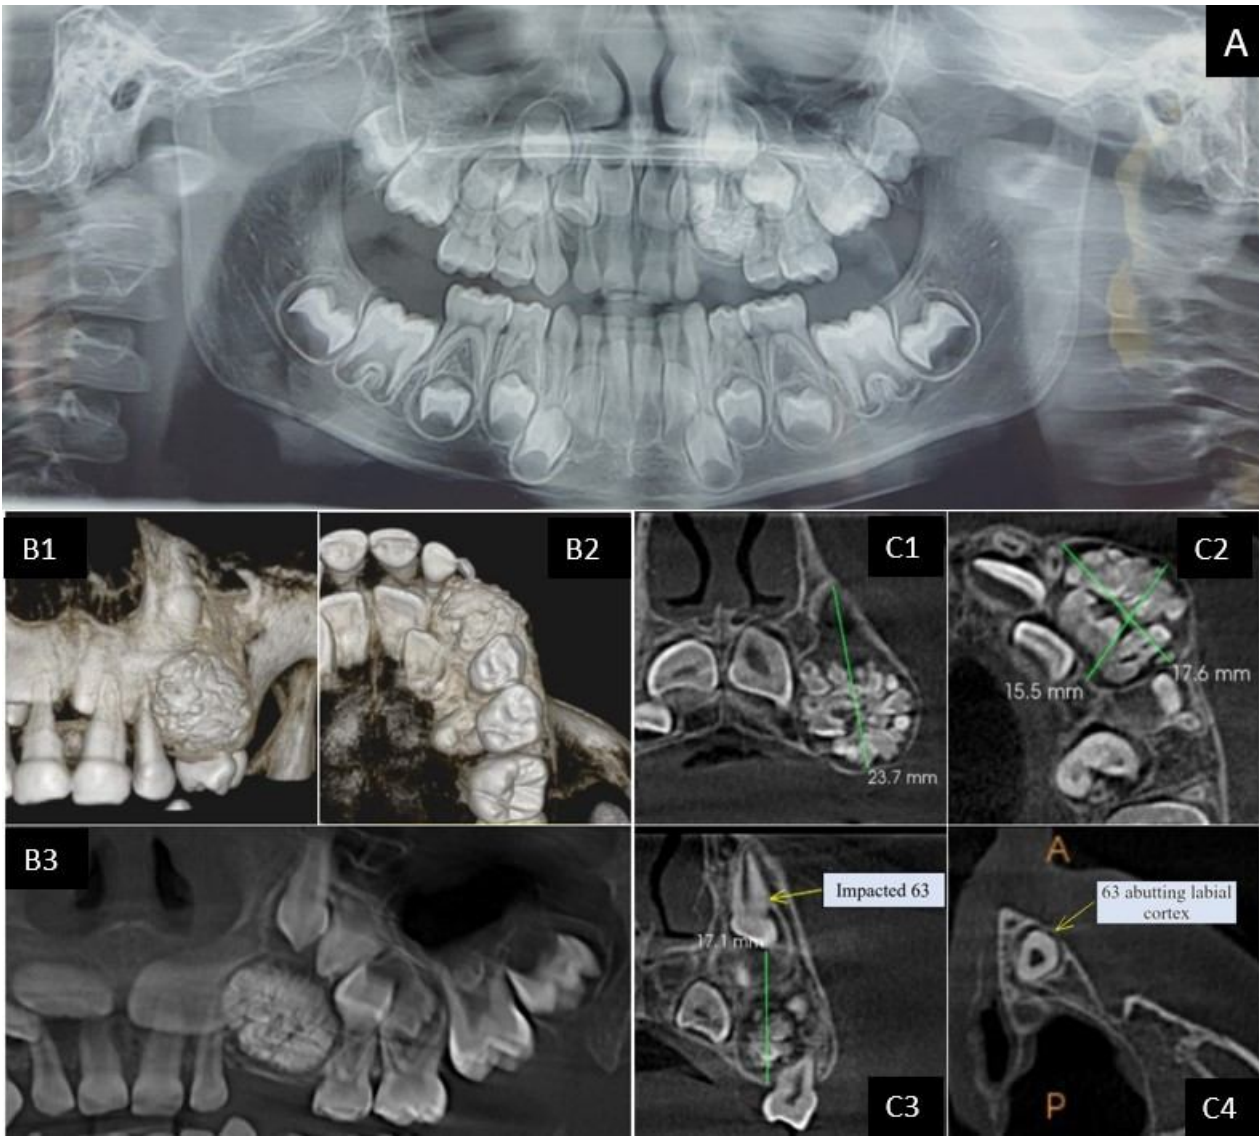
[A] OPG SHOWING RADIOPAQUE MASS RESEMBLING MULTIPLE SMALL TOOTH-LIKE STRUCTURES IN THE MAXILLARY LEFT ANTERIOR REGION; RECONSTRUCTED CT IMAGES IN FRONTAL [B1] AND OCCLUSAL [B2] 3D VIEW AND PANORAMIC VIEW [B3]; [C1-C4] REFORMATTED MULTIPLANAR IMAGES THROUGH LEFT MAXILLA
